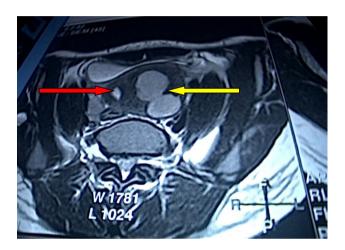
MRI of pelvis showing uterine septum dividing endometrial cavity asymmetrically into normal right-sided uterine cavity (red arrow) and left-sided (yellow arrow) non-communicating endometrial cavity
